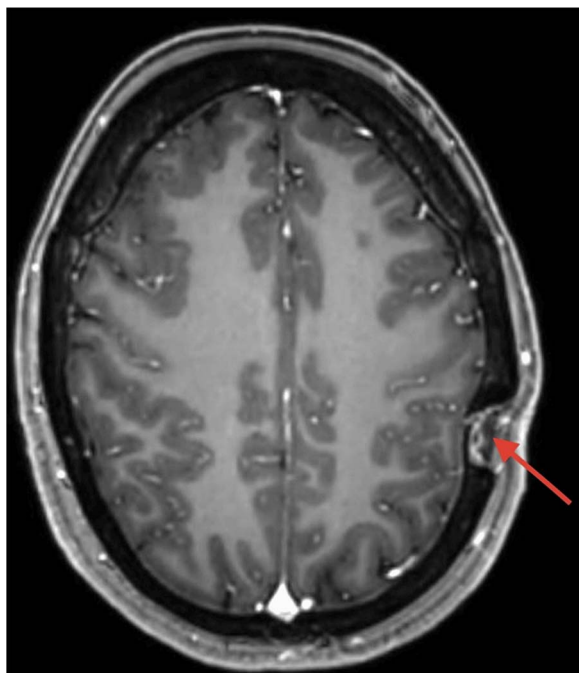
MRI with contrast showing lesion (arrow) in the left parietal bone.
